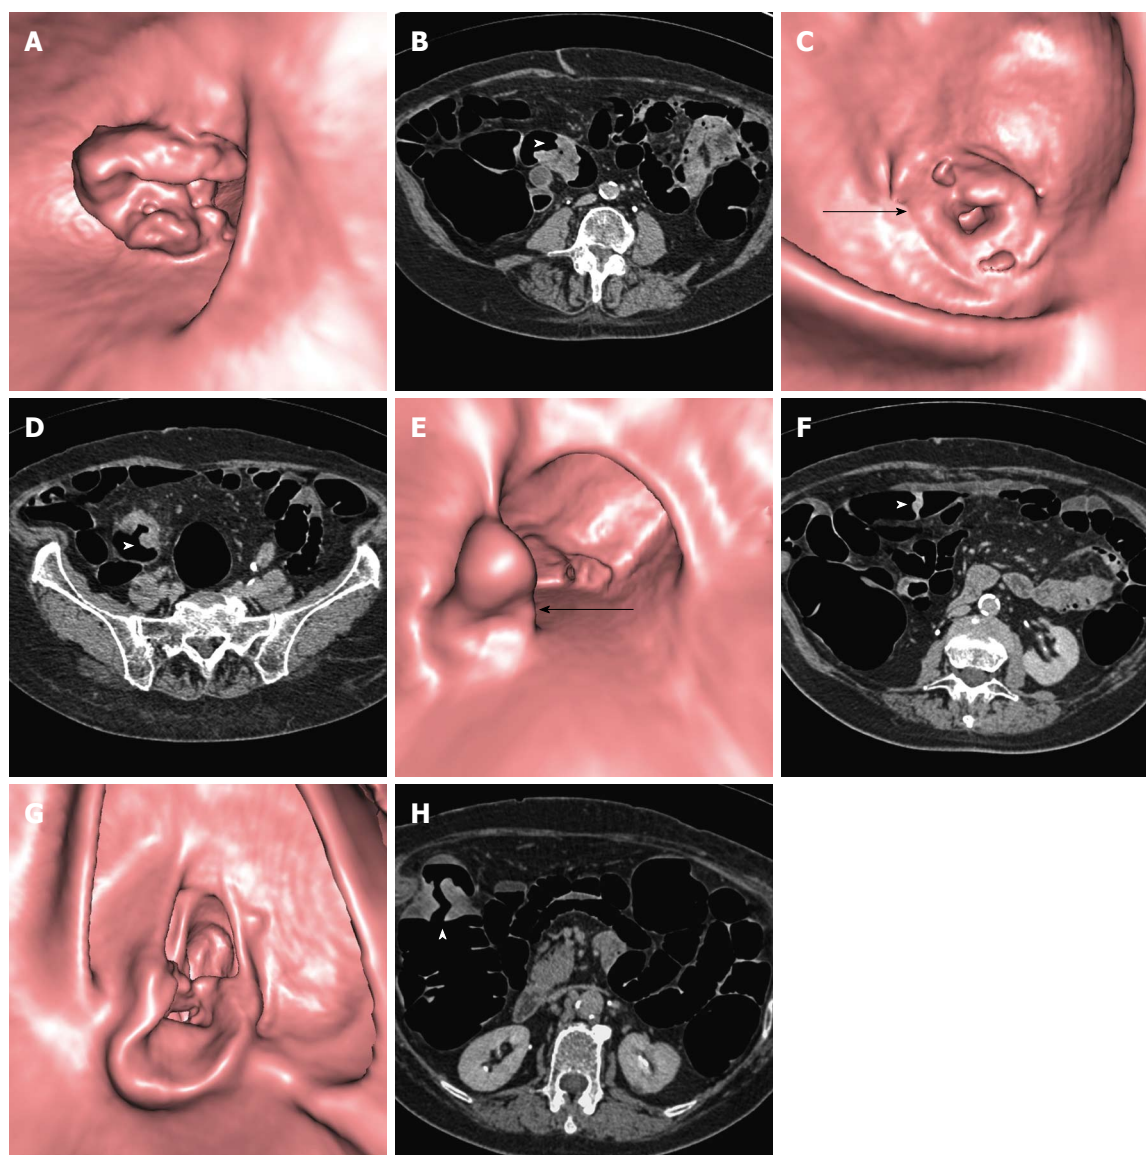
Computed tomography colonography performed in an 83-year-old female with incomplete colonoscopy due to stenosing adenocarcinoma of the sigmoid colon. Computed tomography colonography (CTC) identified three other synchronous colonic tumors confirmed as adenocarcinomas at surgery. CTC endoluminal and axial source images are shown. A, B: Distal stenosing lesion of the sigmoid (arrowhead); C, D: Proximal stenosing lesion of the sigmoid (arrow and arrowhead); E, F: Vegetating lesion of the transverse colon (arrow and arrowhead); G, H: Stenosing lesion of the right flexure (arrowhead).
